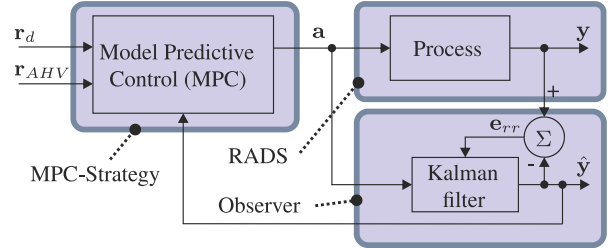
Model-predictive control (MPC) strategy is used to steer the robotically actuated delivery sheath (RADS). The referenced tip position by the clinician is denoted by \mathbf{r}_d , while \mathbf{r}_{AHV} describes the position of the aortic heart valve with *a priori* knowledge obtained from pre-operative ultrasound images. The tip position obtained by ultrasound image segmentation is denoted by \mathbf{y} , with corresponding filtered position described by $\hat{\mathbf{y}}$. The arc parameters denoted by \mathbf{a} is provided as an input to the RADS and the Kalman filter. The resulting positioning error is given by \mathbf{e}_{rr} , which is used to adapt the Kalman filter.
